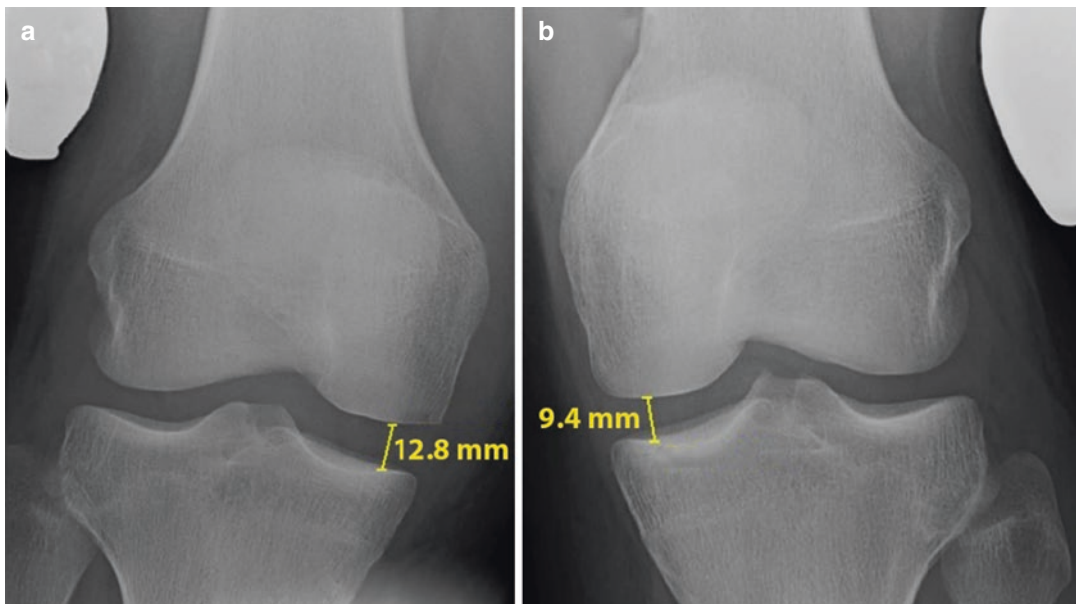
Valgus stress radiographs obtained in 20° of flexion demonstrating medial knee laxity. (a) The injured right knee demonstrates 12.8 mm of medial gapping on valgus stress testing, compared to (b) the contralateral
